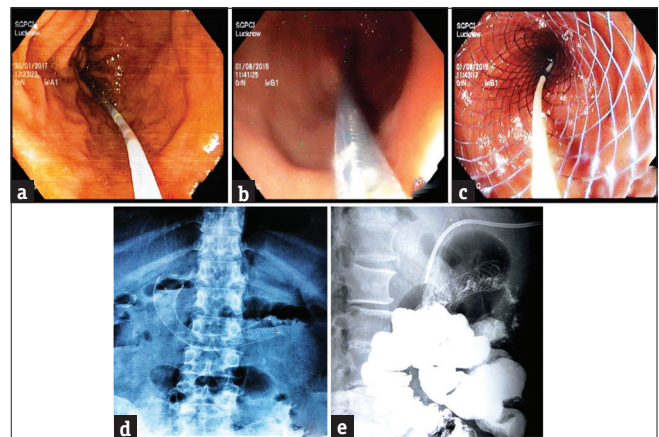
Endoscopic view of guidewire placement and stent deployment (a-c), plane X-ray abdomen showing stent position (d), oral barium contrast study showing passage of contrast through self-expanding metal stent (e)
